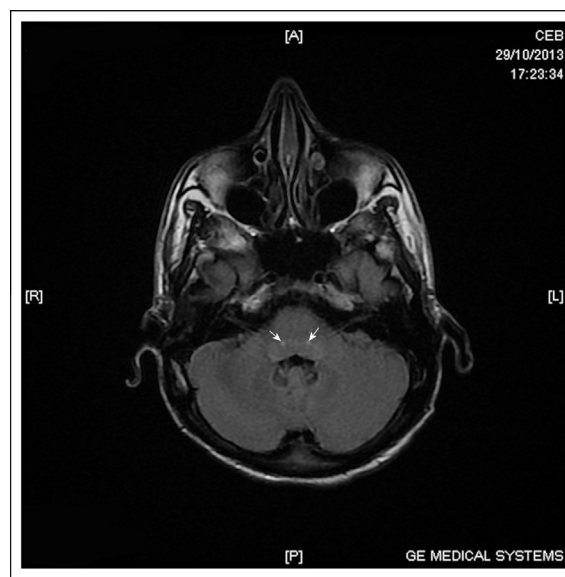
MRI showing two bilateral punctiform (arrows) increased signal on T2 together with fluid attenuation inversion recovery (FLAIR) in the pons.
